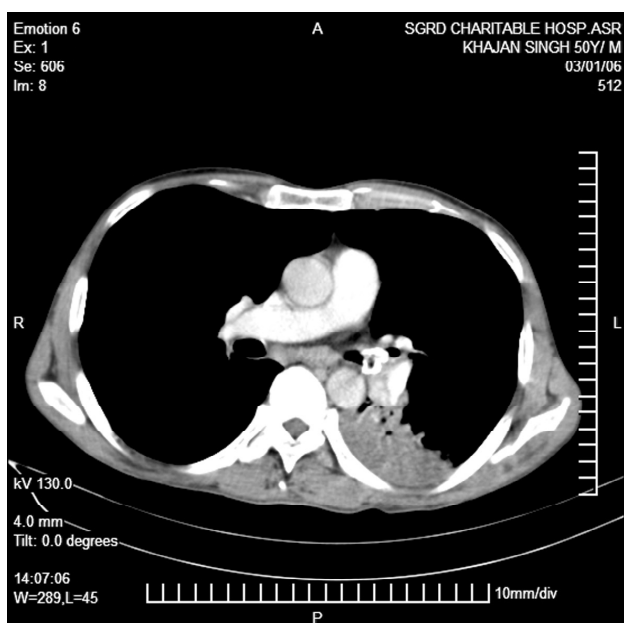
CT thorax showing a hyperdense lesion (foreign body) occluding the left lower main bronchus with collapse/consolidation of the left lower lobe.
